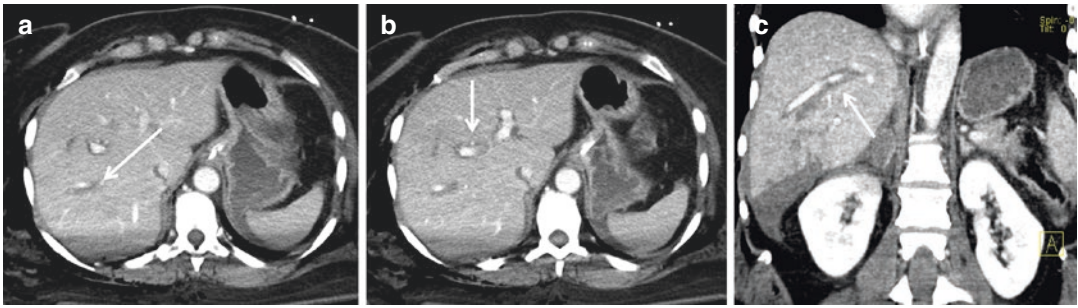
(a, b) Axial CT scans and (c) coronal reconstruction show the periportal tracking characterized by hypodensities of periportal fat tissue (arrows)
